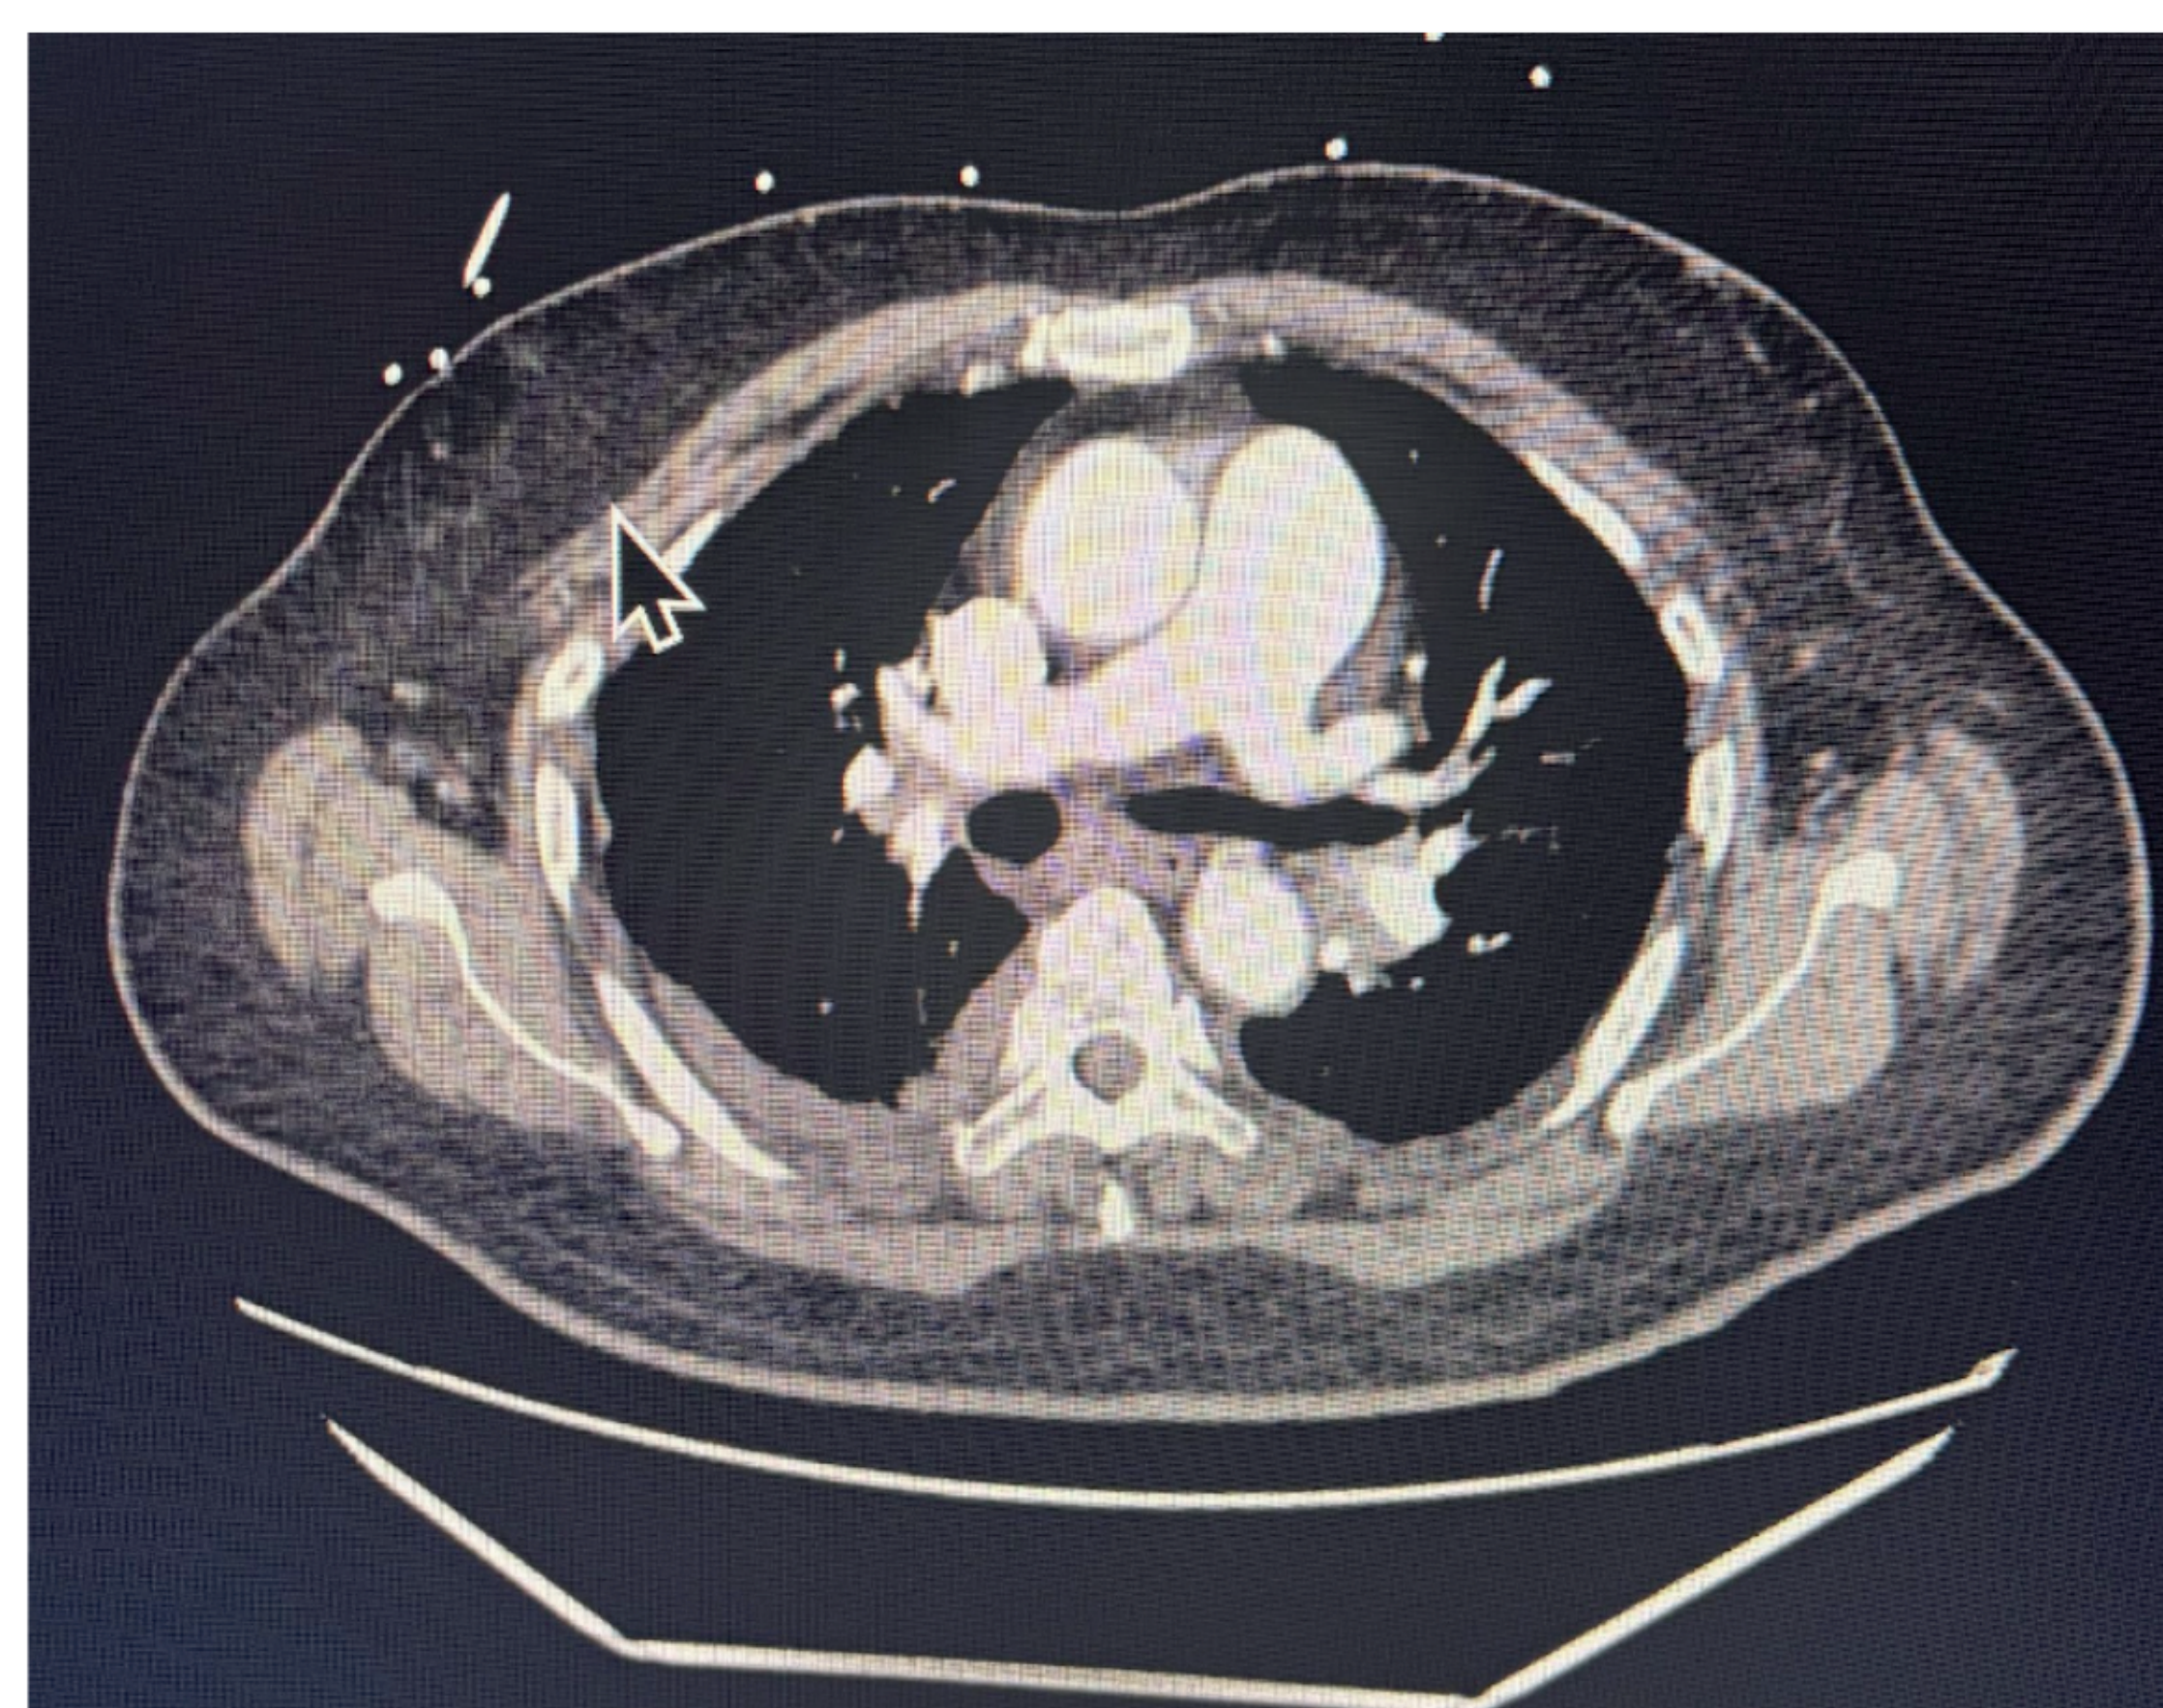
CT angiogram of the chest following the injection of IV contrast showing main pulmonary artery at bifurcation filled with contrast..indicating a filling defect (there was no evidence of thrombosis).
